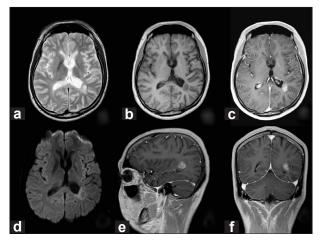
Magnetic resonance imaging revealing a solitary mass lesion in the intraparenchymal region near the ventricular trigone. The mass of high intensity appears on both T2-weighted images (WI) and diffusion-WI (a and d), and that of low intensity on T1-WI (b).Axial, sagittal, and coronal views on T1-WI with gadolinium demonstrate homogenous enhancement of the mass lesion (c, e, and f).The left thalamus and the parietal lobe near the lesion have atrophic changes
